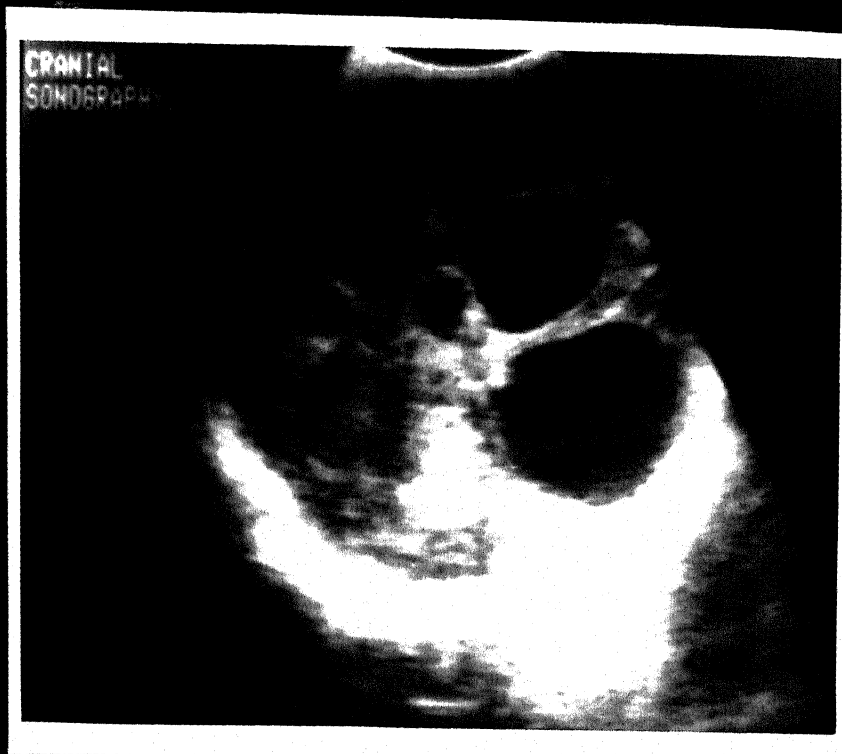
Coronal sonogram showing dilated lateral and third ventricles: Aqueductal Stenosis
